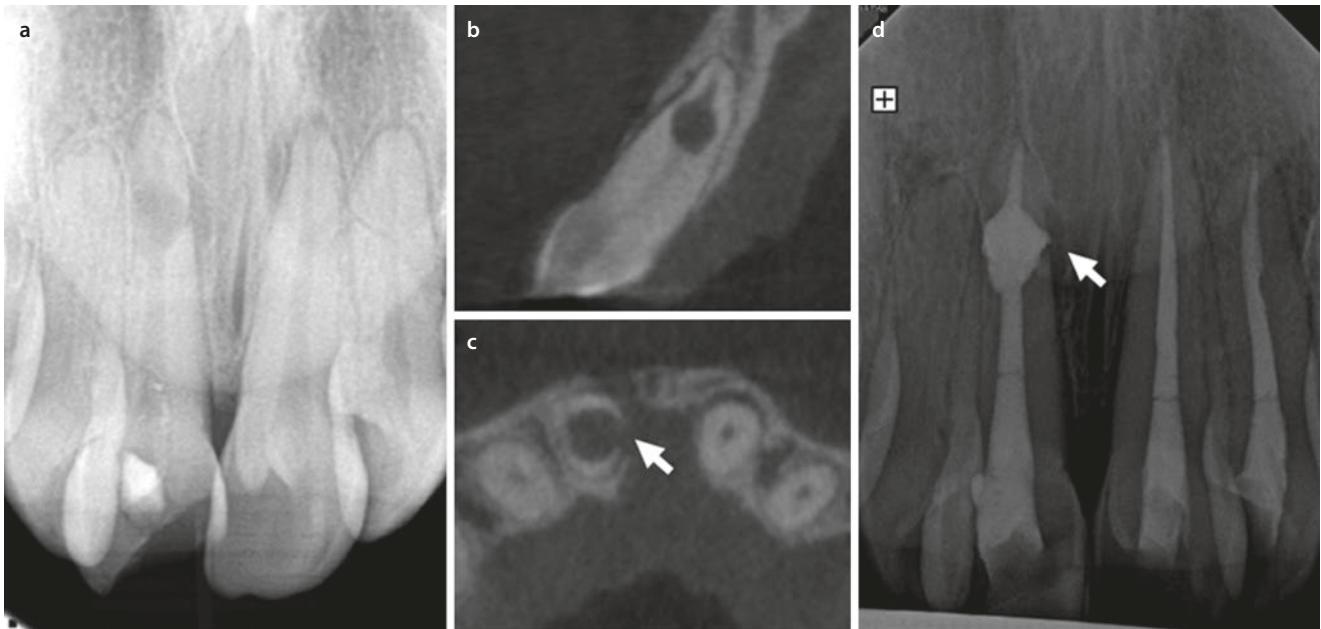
a Pre-operative radiograph of IR on tooth #9 with history of lateral luxation and complicated crown fracture; previously initiated by referring dentist. The CBCT coronal b and axial c orthogonal planes
